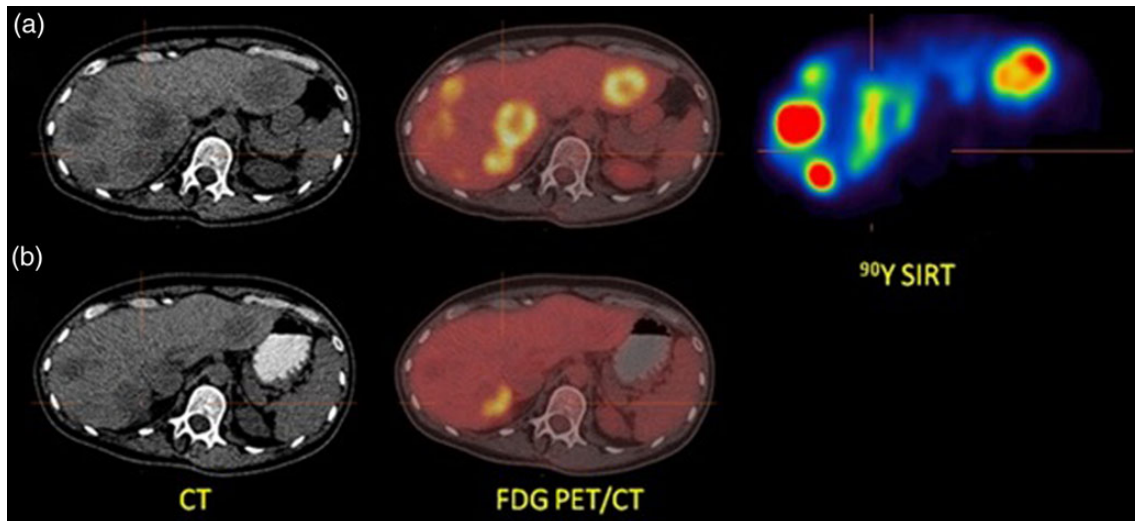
(a) FDG-PET/CT with axial views showing recurrent multifocal hepatocellular carcinoma and perfusion of injected ^{90}Y -tagged resin microspheres. (b) Follow-up FDG-PET/CT at 9 weeks after injection of ^{90}Y microspheres showing a radiological response with tumour necrosis and a near complete metabolic response.
